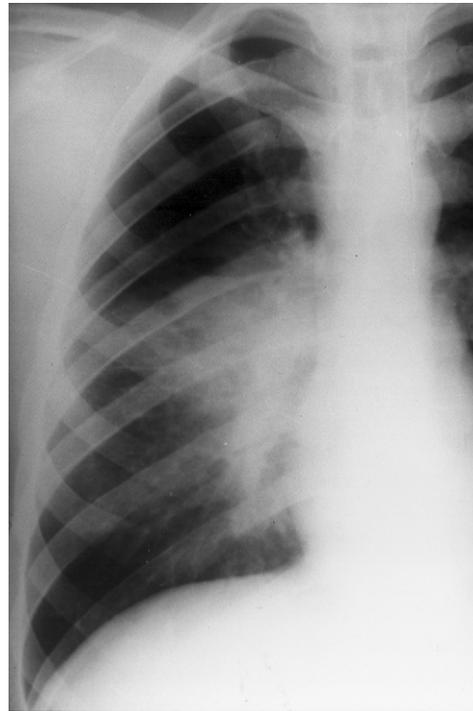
Primary coccidioidomycosis. PA chest radiograph coned to the right lung of a 26-year-old man shows a segmental airspace consolidation overlying the hilum within the superior segment of the lower lobe.
